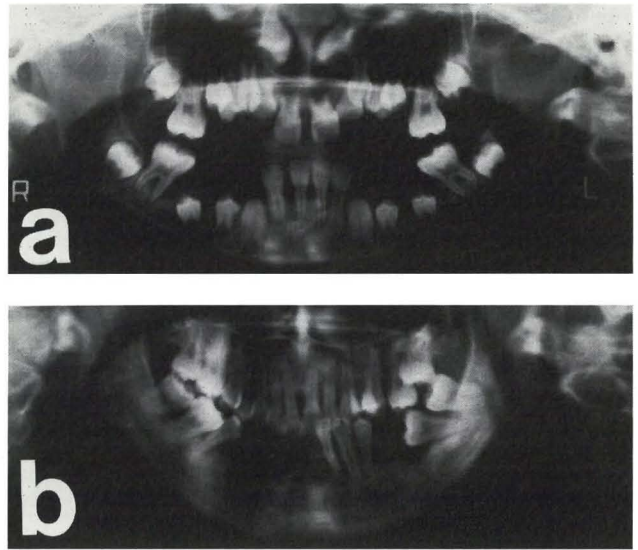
(a) Orthopantomographs of the patient at age eight years and one month. (b) nineteen years and seven months. a: Alveolar bone of mandibular right and left molars has already resorbed. b: Teeth 17, 18, 27, 28, 37, 38, 47 and 48 were migrated mesially.
